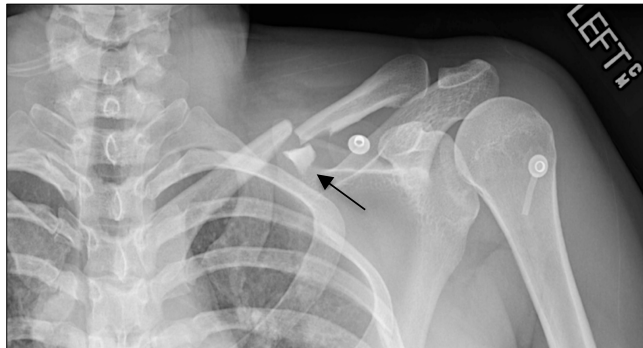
Left Shoulder X-Ray (AP View) revealing a “zed” fragment
